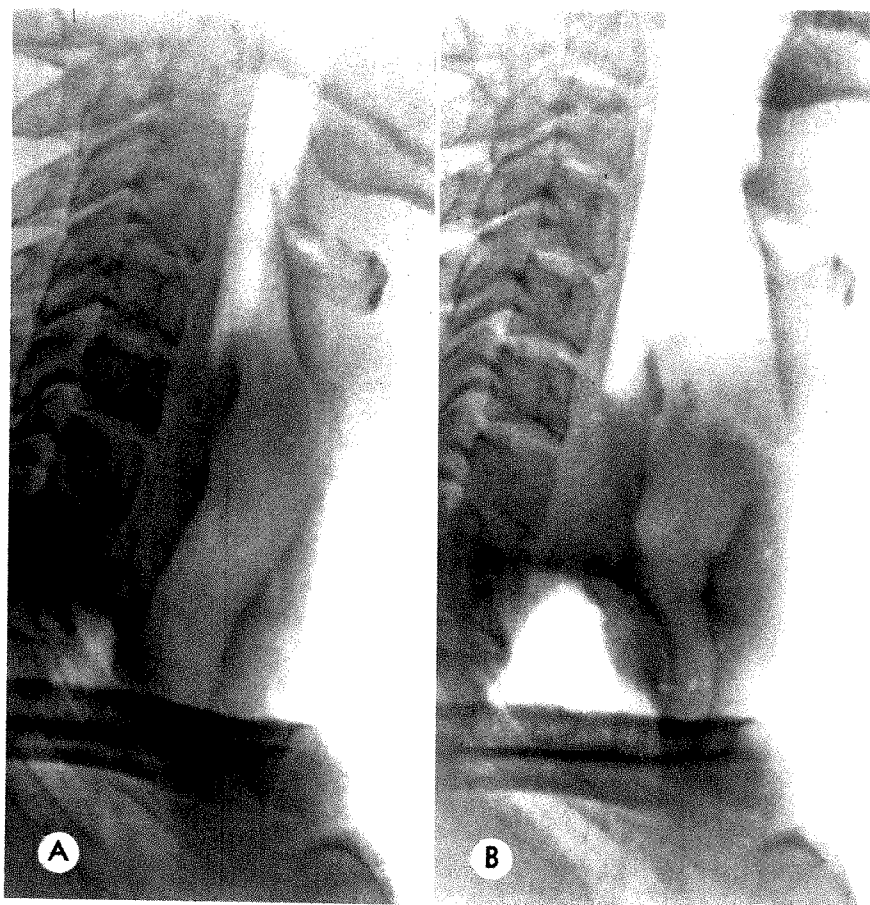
(A) Roentgenogram of an asthmatic patient during respiratory arrest. (B) During "voluntary wheezing expiration" marked narrowing of the cervical part of the trachea occurs.
